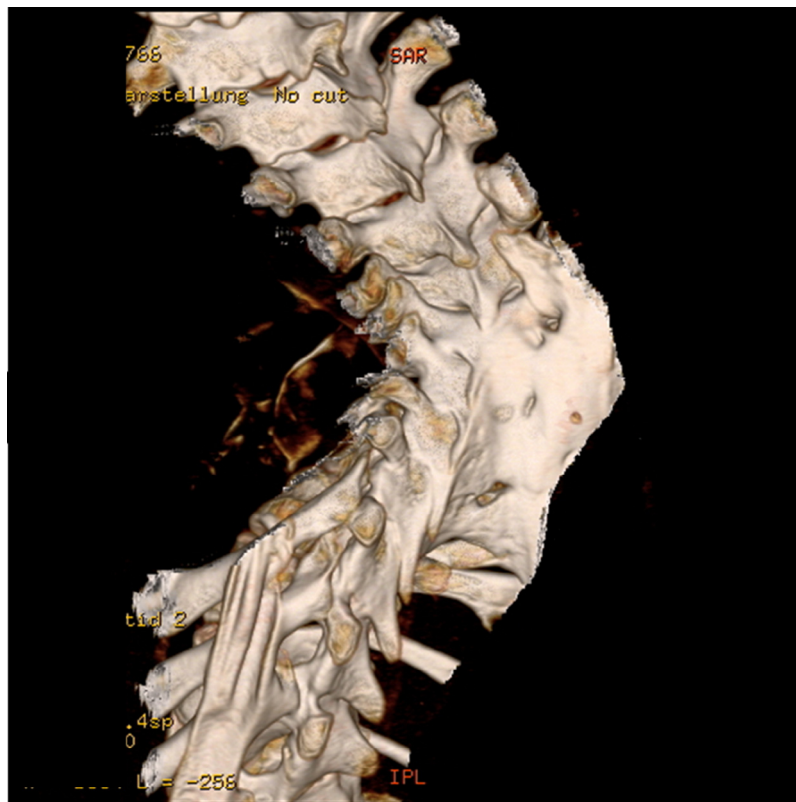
Severe ossifications and autofusion of the spine in a 12-year-old girl with Pierre-Robin-syndrome. Several surgical interventions including implant infection and removal took place before the CT examination with 3D reconstruction. CT, computed tomography; 3D, three-dimensional.
